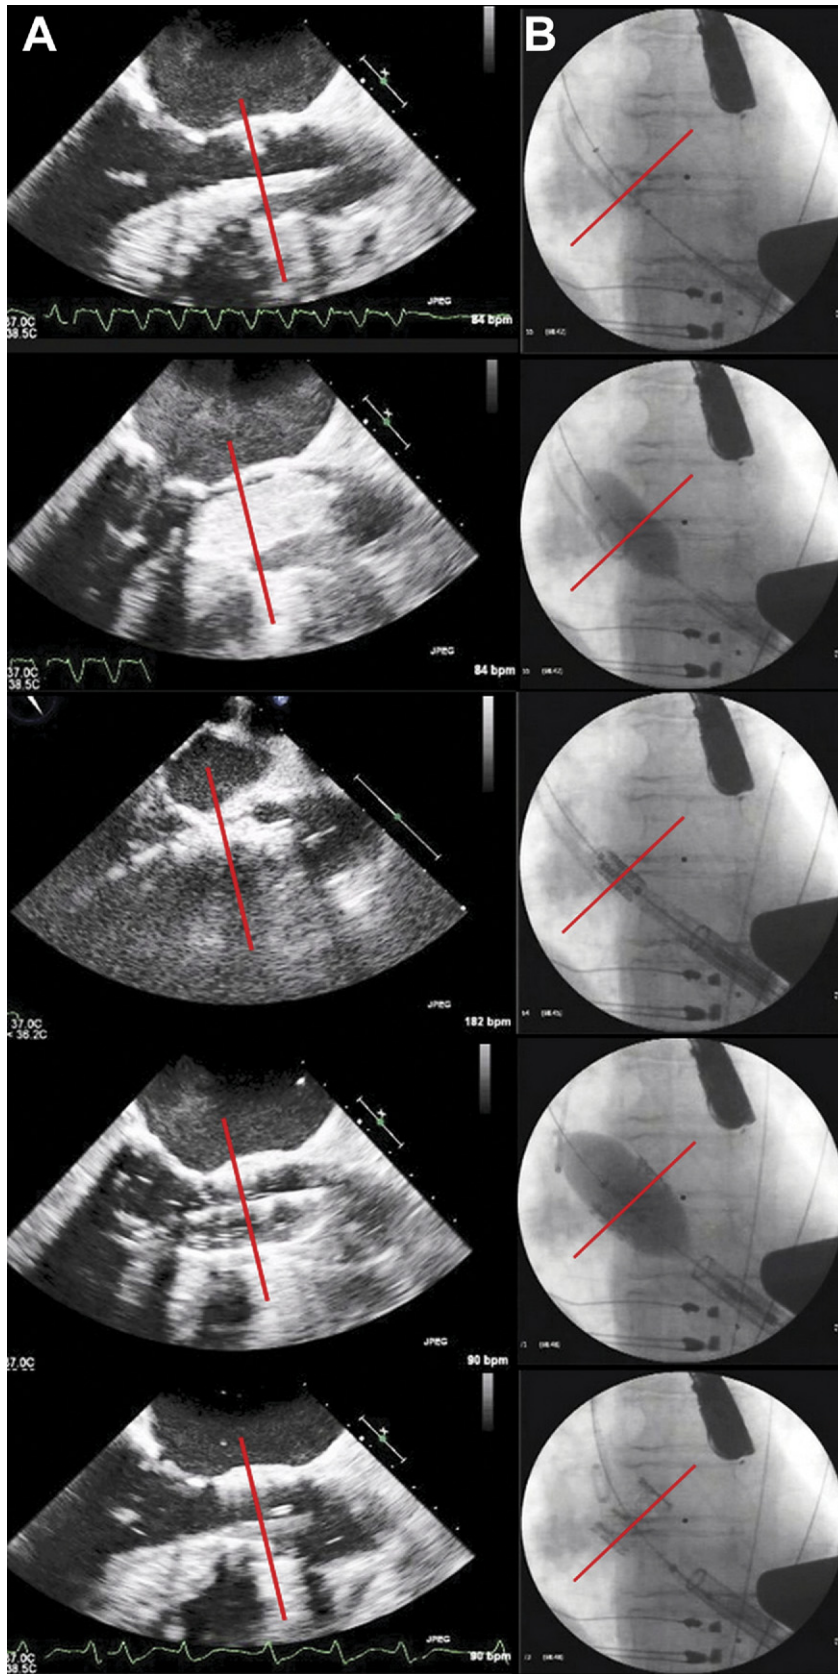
A transapical-transcatheter aortic valve implantation without angiography. (A) Images from the transesophageal echocardiogram showing the key phases of the procedure; the valve ballooning, the stent-valve positioning and the deployment. (B) The same key phases for the Sapien implantation are controlled by a preconfigured fluoroscopy. The red line represents the plane of the native aortic valve.
